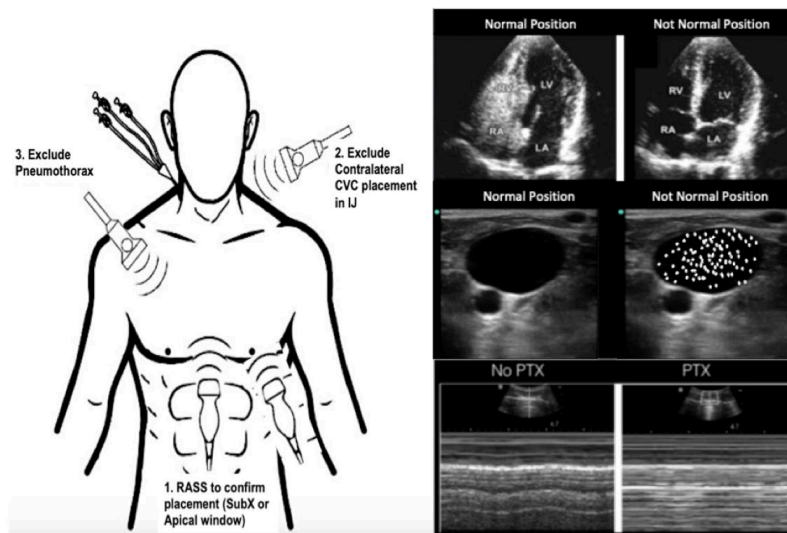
Point-of-care ultrasound-guided catheter confirmation protocol. Image modified from Monrief 2021³
